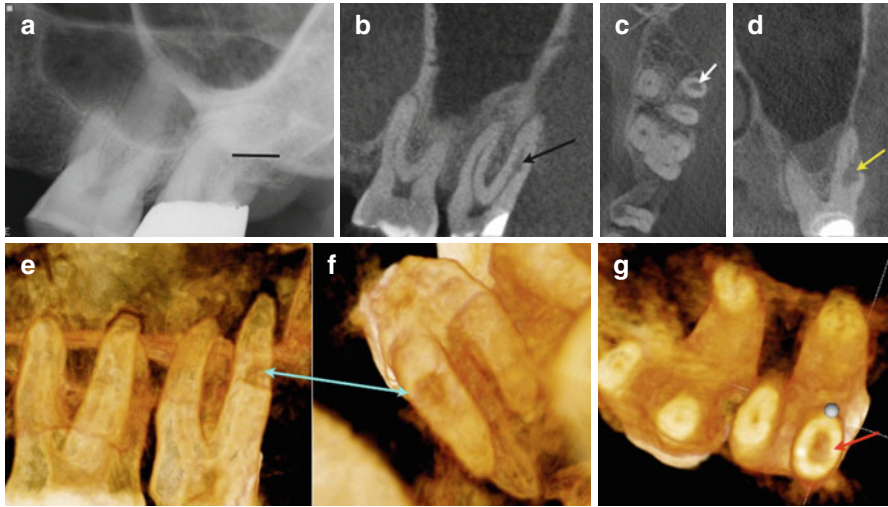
(a) Periapical radiograph of tooth #15. The *line* corresponds to the axial section view in (c). Tooth #15 presented with pain on biting. The tooth was nonresponsive to cold, and periodontal probing depths were WNL. A diagnosis of necrotic pulp and symptomatic apical periodontitis was established. (b) Sagittal view of tooth #15 demonstrating an internal resorptive defect in mid-root of the distobuccal root (*black arrow*). (c) Axial view demonstrating the internal resorptive defect (*white arrow*). (d) Sagittal view demonstrating the internal resorptive defect and distobuccal root fracture (*yellow arrow*). (e, f and g) are 3D reconstructions of tooth #15 demonstrating the internal resorptive defect from different views (*blue and red arrows*)
